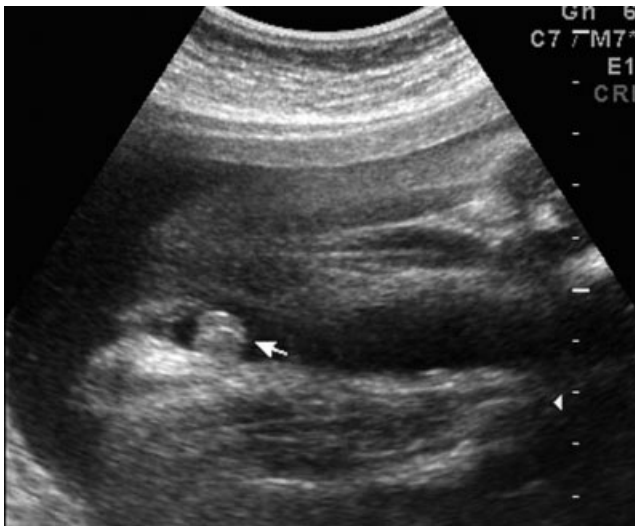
Prenatal sonographic image of female fetal genital prolapse. Axial section of the vulva shows a phallus-like structure (arrow) protruding over the ventral part.
